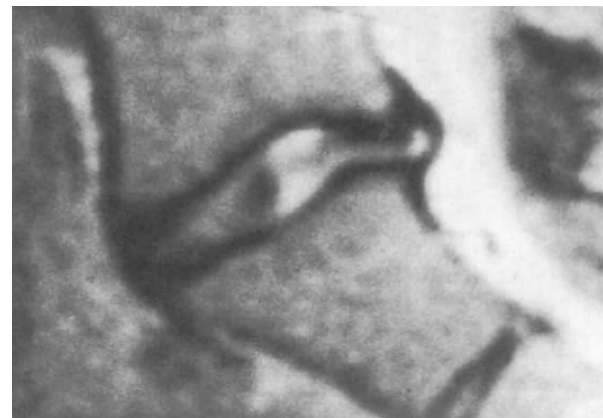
Spin-echo T2-weighted MR image. Hyperintense stria, which from the nucleus pulposus reaches the peripheral portion of the annulus fibrosus.
